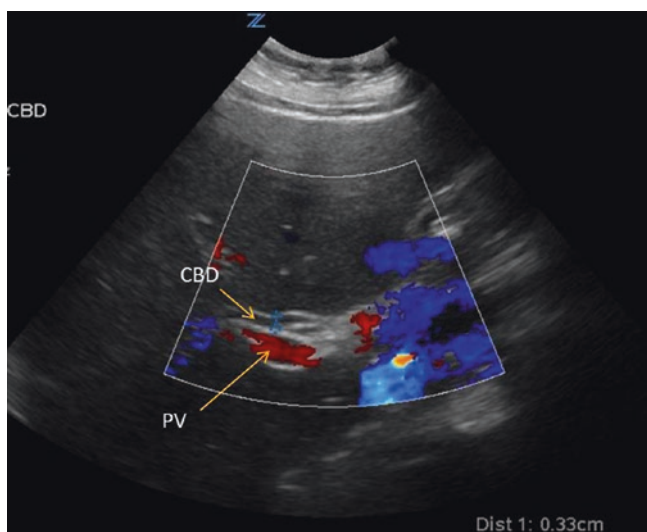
Color flow Doppler of the portal triad in a longitudinal view. *CBD* common bile duct, *PV* portal vein. Image courtesy of Pimpa Limphan-udom
